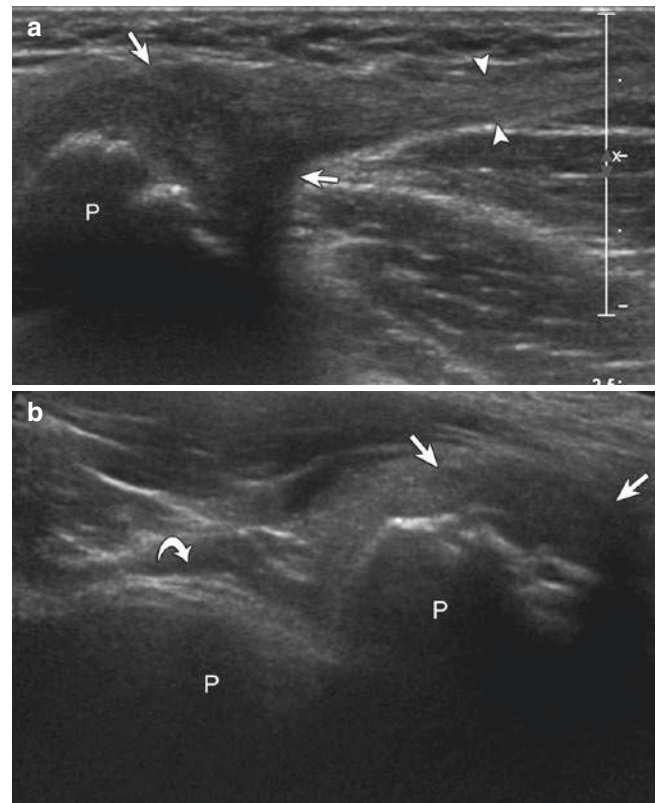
Common aponeurosis injury at pubis (“sports hernia”). Ultrasound images (a) long axis and (b) short axis to proximal adductor longus tendon show (*arrows*) abnormal hypoechoic tendinosis and bone irregularity of common aponeurosis between rectus abdominis and adductor longus over pubis (P). Note normal contralateral common aponeurosis (*curved arrow*)
